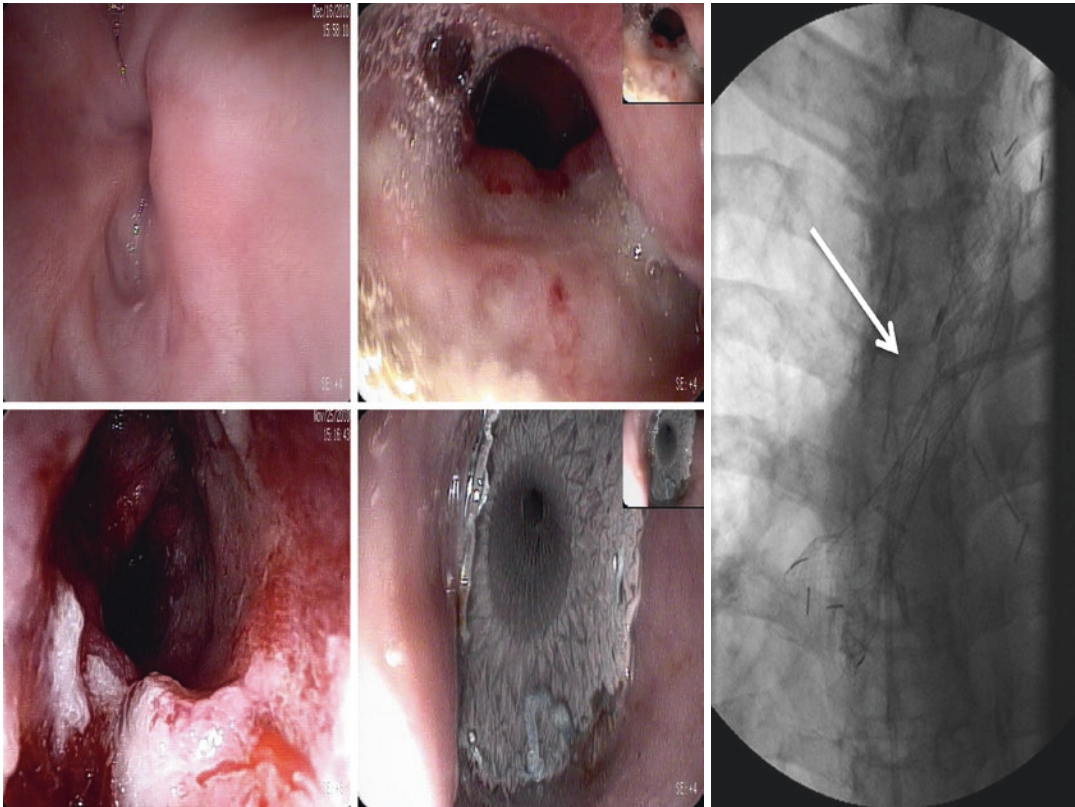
Local failure after distal esophagectomy and proximal gastrectomy for Siewert I cancer. Self-expanding stent in place the radiograph indicates successful placement of stent (*white arrow*)
